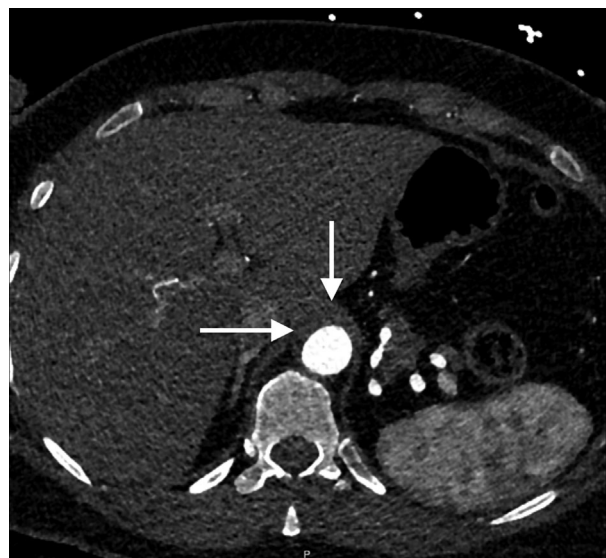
Computed tomography of the abdomen with angiography showed a crescent-shaped area in the descending aorta that did not enhance after intravenous contrast.
